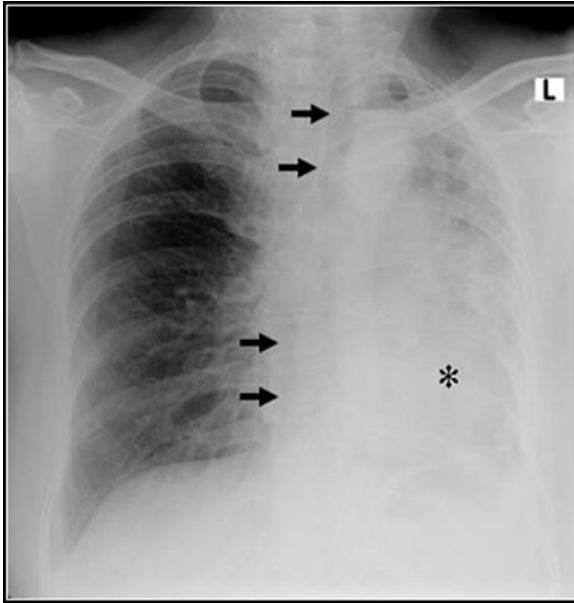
Erect chest radiograph shows reduced left lung volume with tracheal and mediastinal shift to the left side (arrows). There is generalized inhomogenous opacification of the left lung with air bronchogram consistent with collapse consolidation (*). There is crowding of the ribs on left side with elevation of the left hemi-diaphragm.
